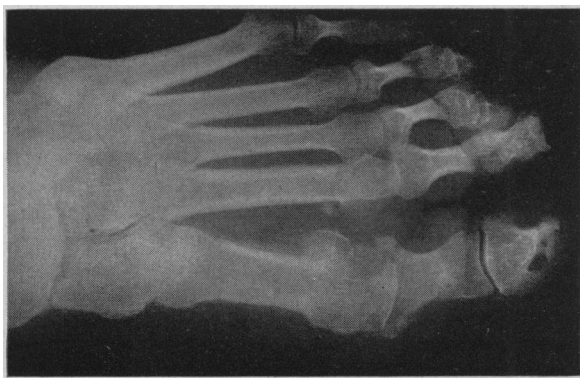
X-ray of left foot revealing destruction of the first metatarso-phalangeal joint and new bone formation in the soft tissues characteristic of a Charcot's joint.
